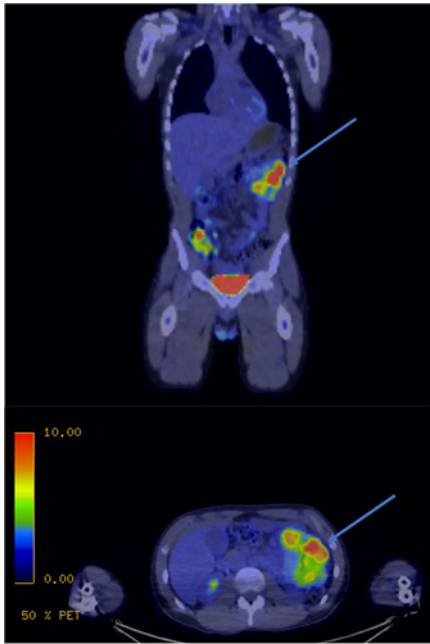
Coronal (top) and axial (bottom) positron emission tomography-CT views demonstrating a hypermetabolic, multi-lobulated, ill-defined mass involving multiple loops of jejunum, identified by blue arrows.
